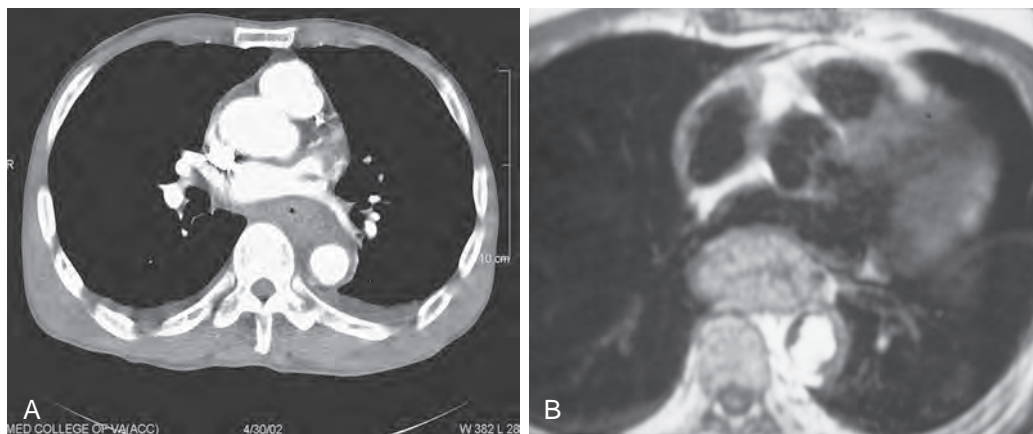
Pericardial invasion by esophageal carcinoma. A. CT scan shows esophageal tumor indenting the posterior wall of the left atrium. This finding is indicative of pericardial invasion. B. MRI scan also shows tumor indenting the posterior wall of the left atrium.
